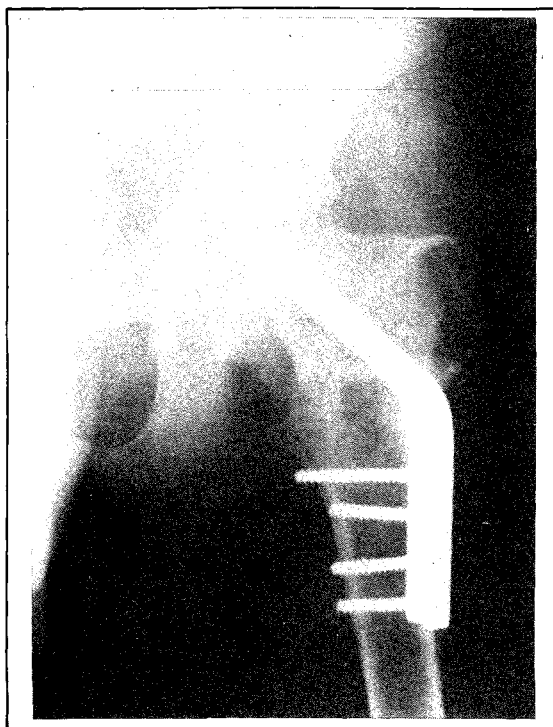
A post-operative radiograph of Case 2, with pseudoarthrosis and osteotomy united and a corrected neck shaft angle.
